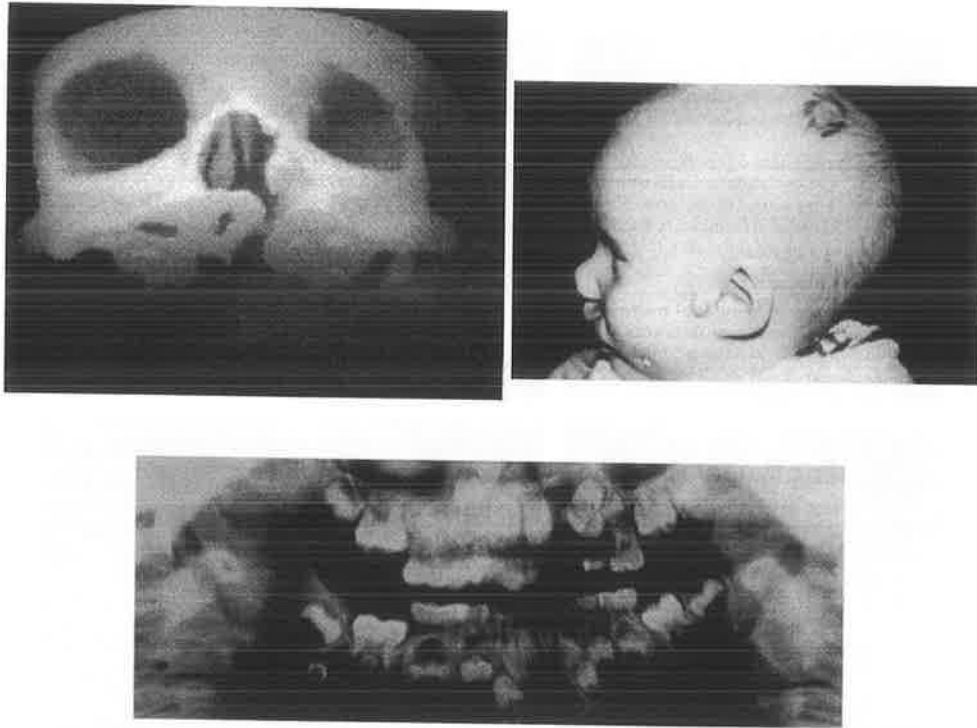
(Above, left) The three-dimensional CT scan shows left orbital hypoplasia. A left unilateral cleft is also seen. (Above, right) Ectopic eye remnants were found in the parietal region. (Below) The left mandibular ramus is short, but the condyle and coronoid process have normal shapes.
